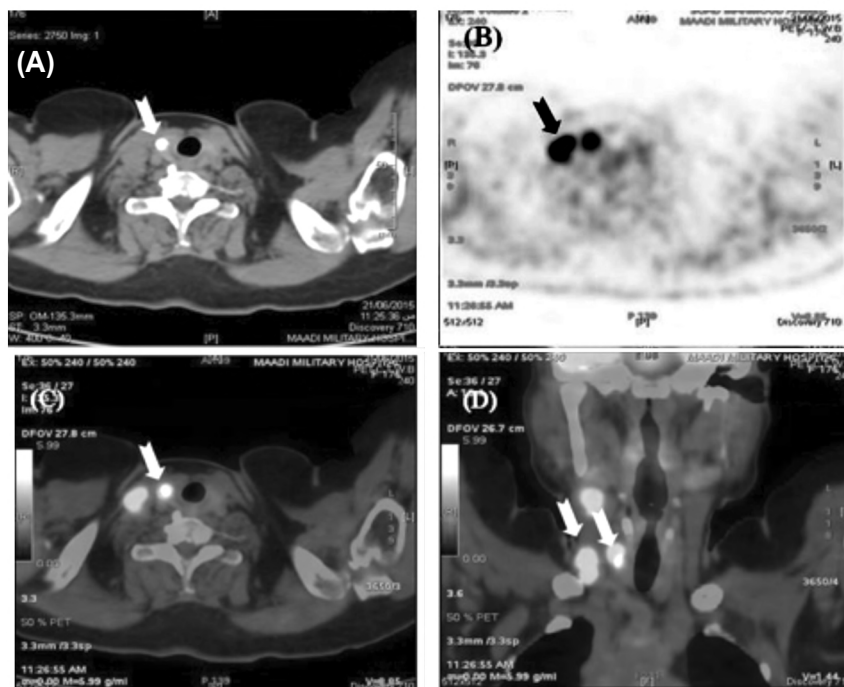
Axial multi-slice (128) non-enhanced CT (A), axial PET (B), axial & coronal PET/CT (C&D) images show a biologically-active calcified nodule in the average sized right thyroid lobe with SUVmax 9.5, associated with enlarged metabolically-active upper and lower right deep cervical lymph nodes and SUVmax. 11 (notched arrows). US images showed a hypoechoic solid nodule measuring 12x10mm with ill-defined outlines and coarse calcification, correlating to the focal uptake on PET-CT scan with multiple enlarged right upper and lower deep cervical lymph nodes showing loss of their hilar fat contents as well. US-guided FNAB was suspicious for a malignant lesion.
